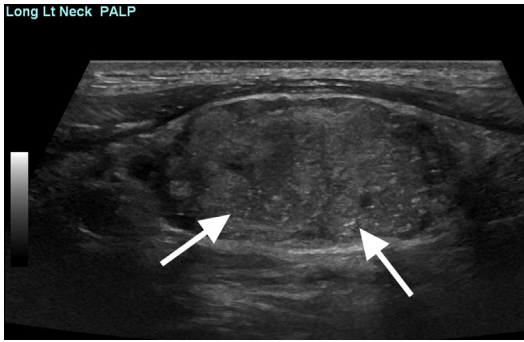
A 30-year-old man with slowly enlarging left neck mass, with biopsy results of metastatic papillary thyroid carcinoma. Longitudinal gray-scale ultrasound showed an enlarged lymph node with loss of echogenic hilum and multiple PEF (arrows).
